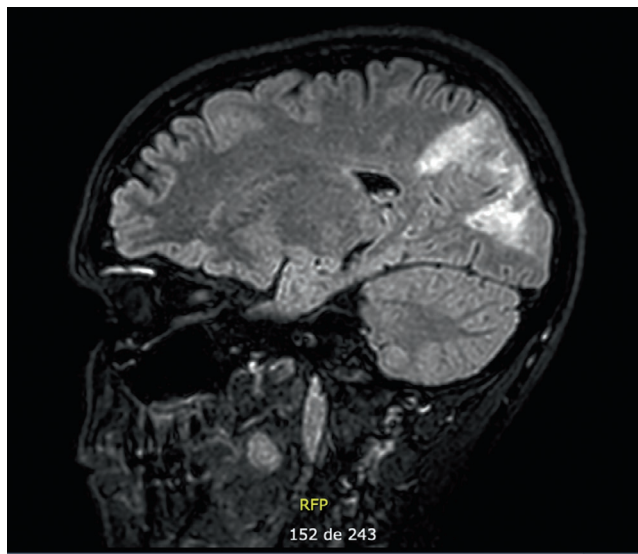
Brain MRI in sagittal flair
